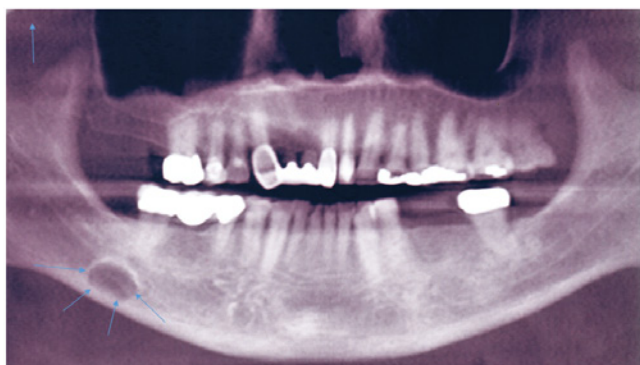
Panoramic radiographic showing elliptical shaped radiolucent lesion (arrows) in molar region of right posterior mandible between inferior alveolar canal and inferior border of mandible.
